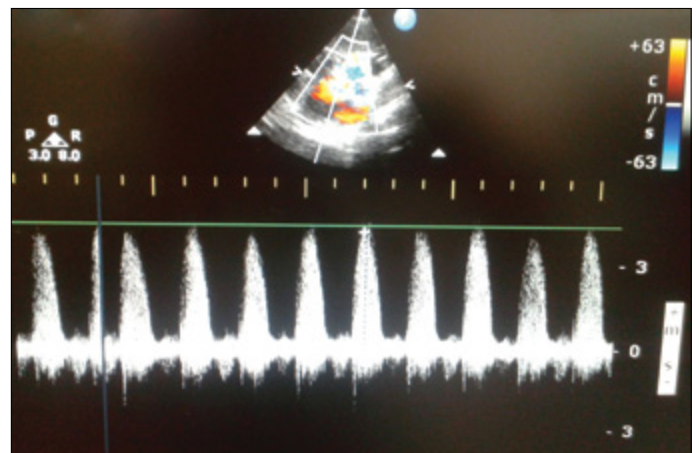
Echocardiographic image of the gradient across the aortic valve before the balloon valvuloplasty procedure
